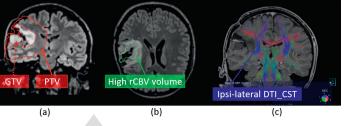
Case presentation. (a) T2 FLAIR MRI with overlaid GTV and PTV contours. (b)T2 FLAIR MRI overlaid with volume with elevated rCBV (correlating with aggressiveness. (c) DTI tractography, note how the ipsilateral DTI_CST is next to the tumour area
